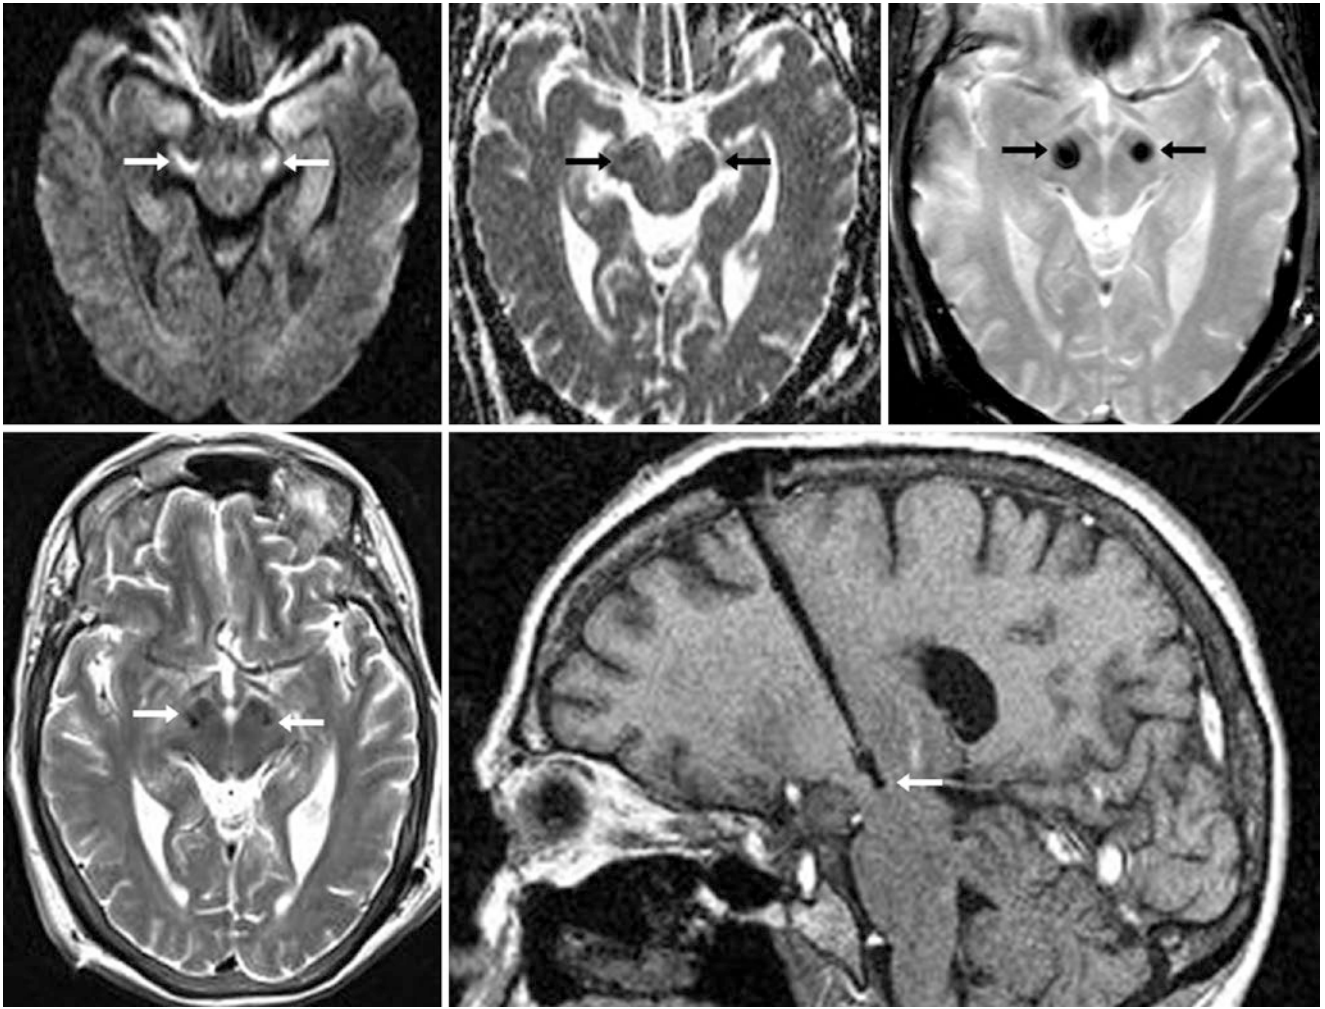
A 65-year-old with “blooming” susceptibility artifacts (arrows) on 1.5 T DWI MRI (*top left*) from bilateral deep brain stimulators (for parkinsonism) with their tips in the tops of the cerebral peduncles or subthalamic regions. Though not easily visualized on the ADC
